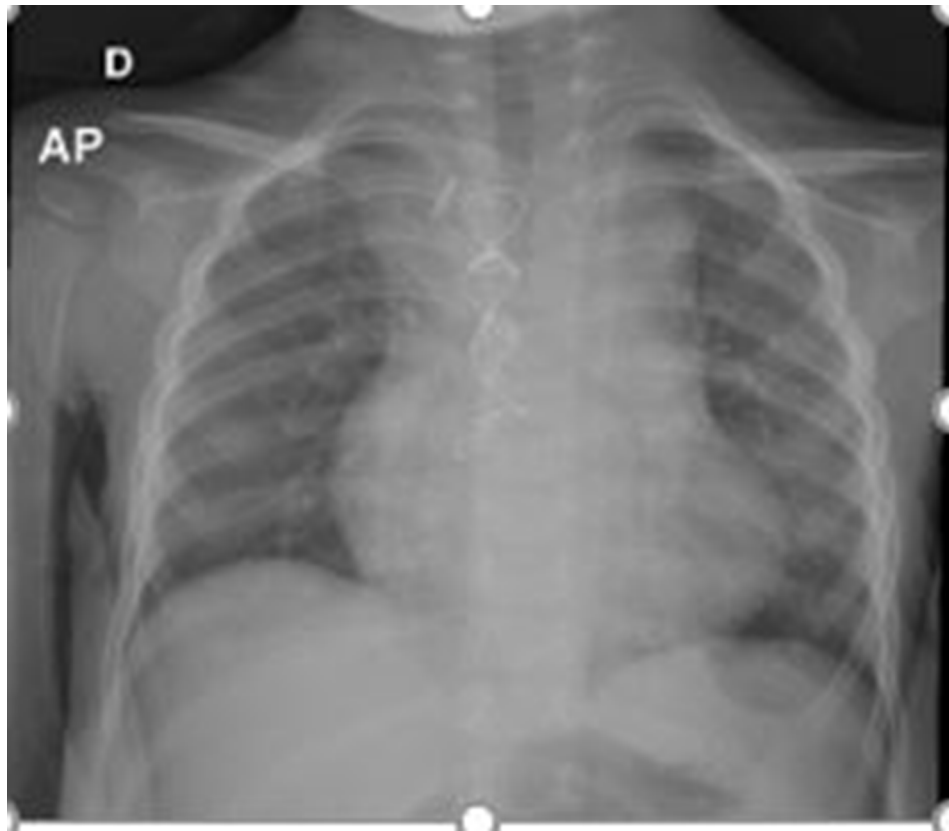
Findings on chest x-ray.  Mediastinal widening. Poorly visualized aortic arch. Magnified global cardiomegaly. Pulmonary hila without lesions. Adequately expanded lungs with no evidence of focal lesions, pleural effusion, or pneumothorax
